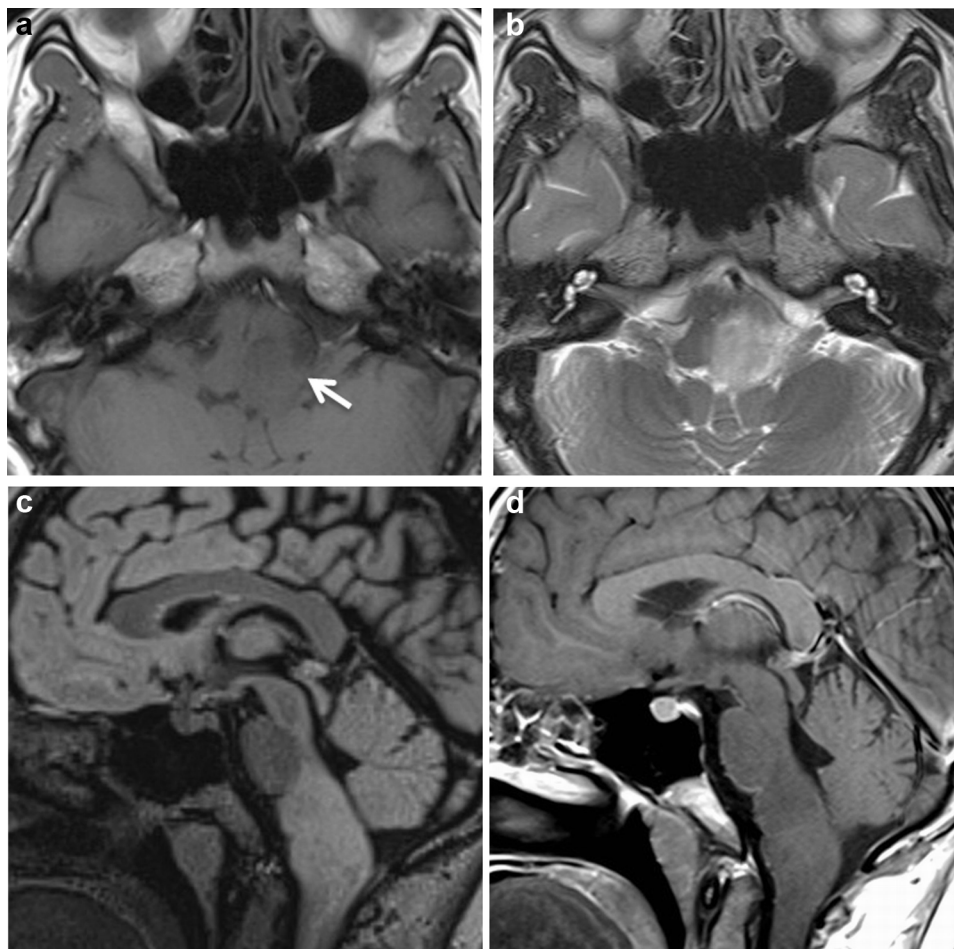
A 24 year-old female patient presenting with left lower cranial nerve palsies. Baseline MRI findings are compatible with a diffuse low-grade ponto-medullary glioma. (a) Axial T1W MR image shows an expansile poorly demarcated iso-hypointense tumour (arrow) involving the left side of the medulla. (b) Corresponding axial T2W MR image shows the tumour to be hyperintense as compared to the rest of the brain parenchyma. (c) Corresponding sagittal FLAIR MR image shows the tumour to be diffusely infiltrative with hyperintense signal. (d) Corresponding contrast-enhanced sagittal T1W MR image shows no contrast enhancement within the tumour.
